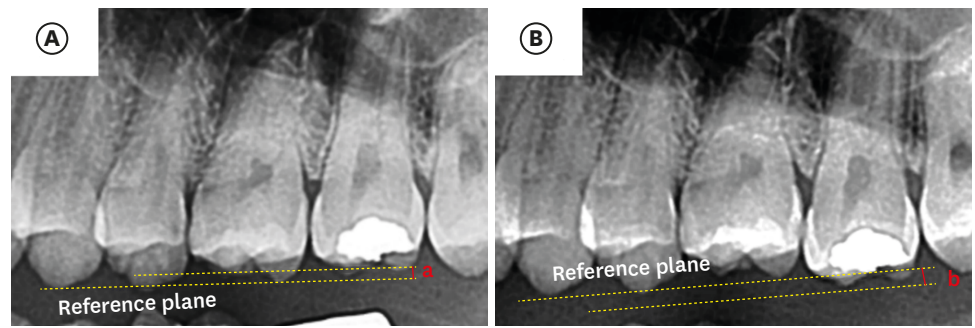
Radiographs with measurements obtained (A) before and (B) after extraction of the mandibular second molar. The vertical distance from the highest cusp tip of the maxillary second molar to the plane connecting the cusp tips of the maxillary first and second premolars and the first molar was measured on panoramic radiographs obtained before extraction and immediately after implant placement. The measured value was expressed as a negative value when the cusp tip of the maxillary second molar was positioned apical to the reference plane and as a positive value when it was positioned coronal to the reference plane.
